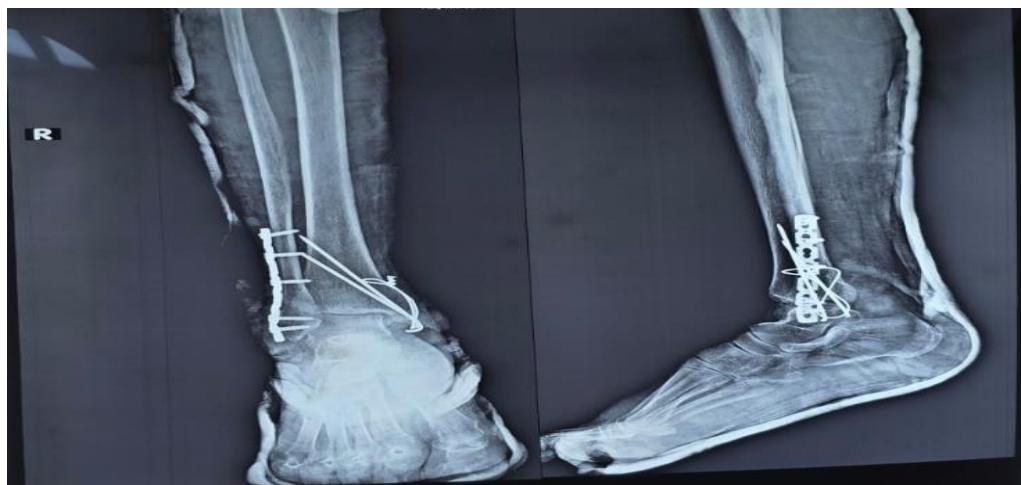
Pre Op Xray showing Bimalleolar fractureFig 6: TBW Post OP XrayFig 7: Post OP Screw Fixation Xray
